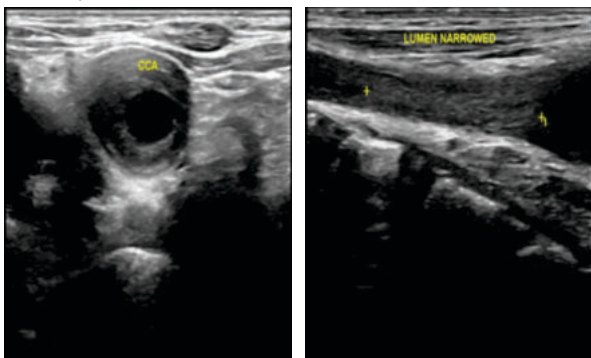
CASE 2: B mode Ultrasound shows the presence of echogenic circumferential increase in wall thickness of the common carotid artery with luminal narrowing.
